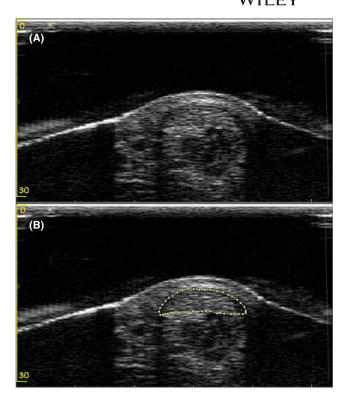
Ultrasound Scan of the Achilles tendon at 25% distal length (A). Manual analyzation of the CSA with ImageJ (B)
